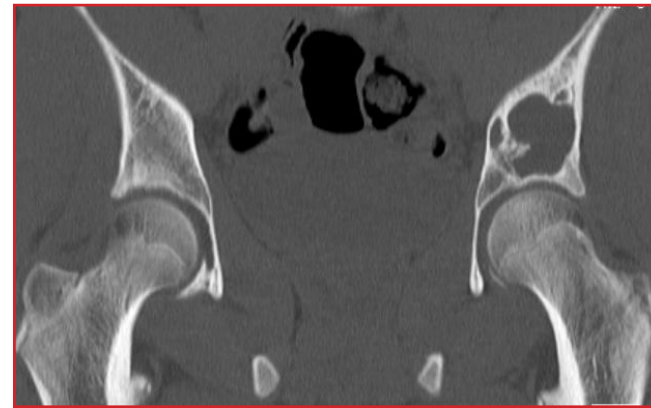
Scans of the pelvis obtained at 10 months after the first procedure reveal reappearance of the lesion in the left ilium. (A) Radiograph. (B) Computed tomography image.
